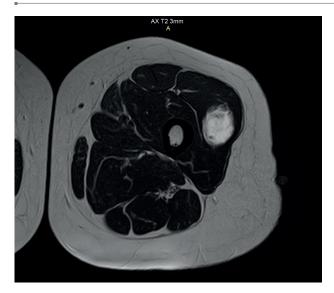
MRI image of the tumor in T2 sequence.
